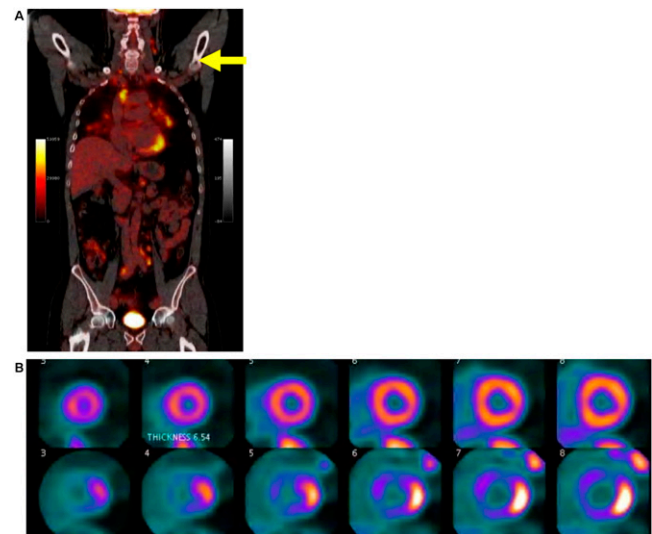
Electrophysiologic implications of PET-defined, active cardiac sarcoidosis. (A) Whole-body FDG PET. (B) Top: ^{82}Rb PET; bottom: ^{18}F -FDG PET. Focal myocardial uptake was associated more strongly with implantable cardioverter defibrillator discharge (accuracy 78%) than other clinical and imaging parameters. FDG PET may thus be useful not only in primary detection but also in risk stratification of patients with known cardiac sarcoidosis.
